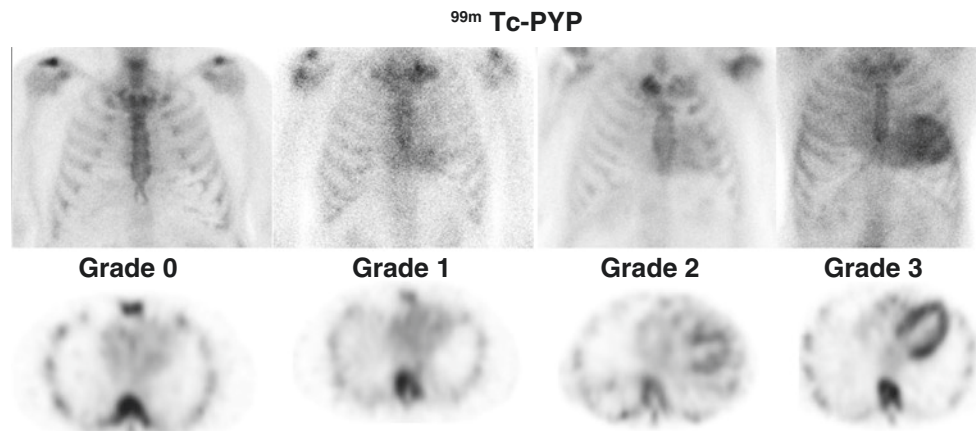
^{99m}Tc -pyrophosphate (^{99m}Tc -PYP) planar and SPECT chest images for the diagnosis of ATTR cardiac amyloidosis. From left to right, the images show grade 0 (no myocardial uptake), grade 1 (myocardial uptake < rib uptake), grade 2 (myocardial uptake = rib uptake)
